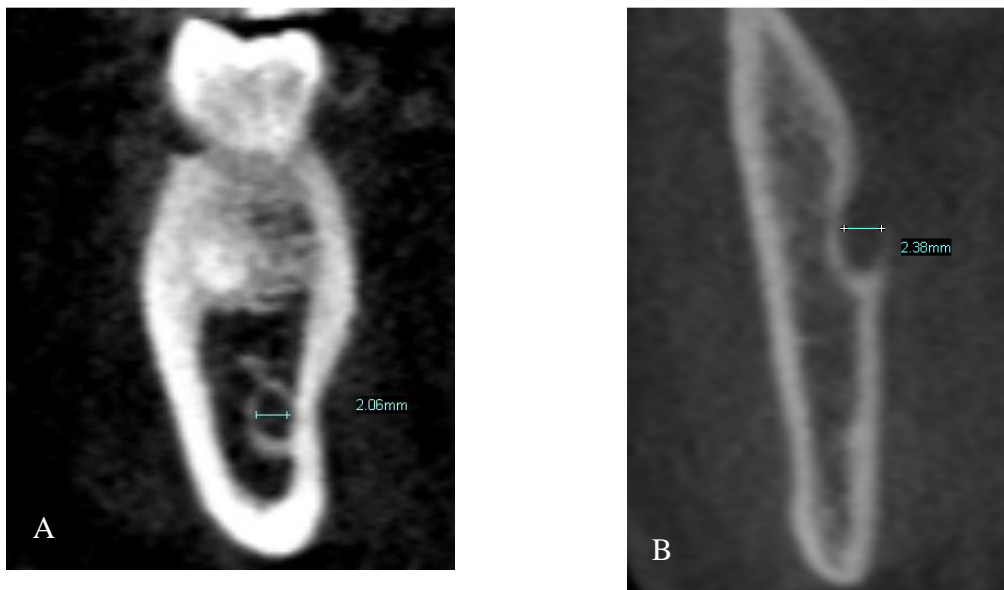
A: Mandibular canal diameter measurement . B: mandibular foramen diameter measurement – coronal view of CBCT image improved with SimPlant software.
